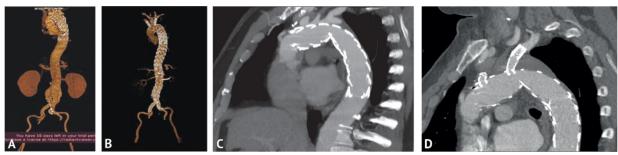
A–B — Computed tomography-angiography of stages of hybrid endovascular aortic repair. A - hybrid prosthesis of the thoracic aorta to the diaphragm; C - total hybrid aortic grafting. CD - final result, complete debranching of the aorta (computed tomography-angiography). Recanalization of the right (C) and left (D) subclavian arteries by retrograde graft fenestration
